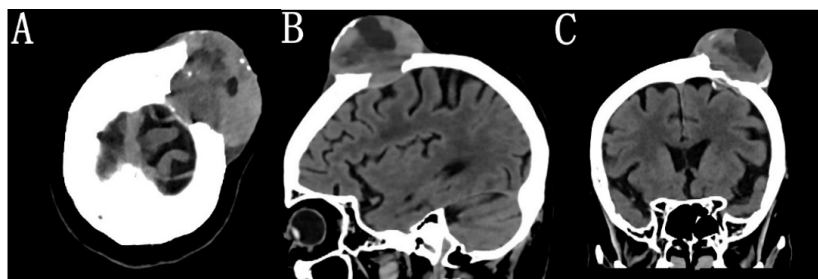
Head CT mass with uneven density, large patchy hypodense necrotic areas and a few calcified shadows; adjacent bone can be seen damaged, but no obvious sclerotic edges are seen.
